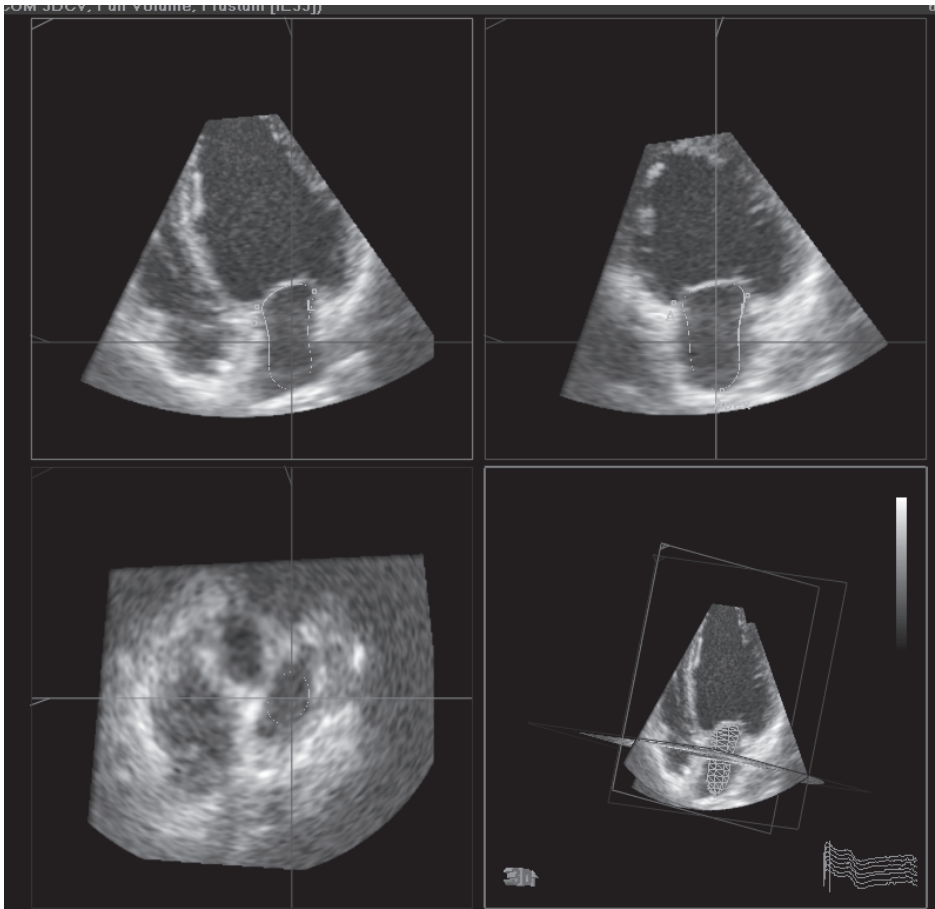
Real-time three-dimensional echocardiography for the assessment of LA volumes. Automatic border detection can be applied to the apical 4-chamber and 2-chamber view (upper panels) for quantification of LA volumes.
